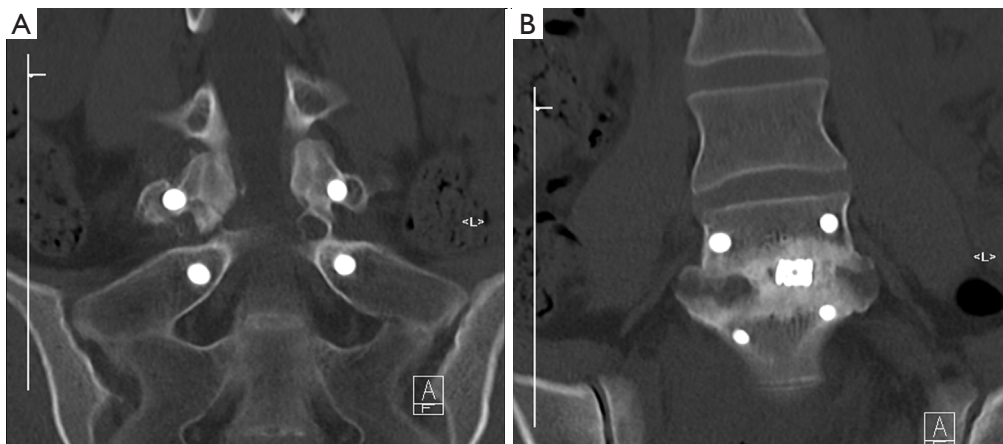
Postoperative 6-month CT scan confirming: (A) posterolateral bone fusion; (B) interbody fusion. CT, computed tomography.
